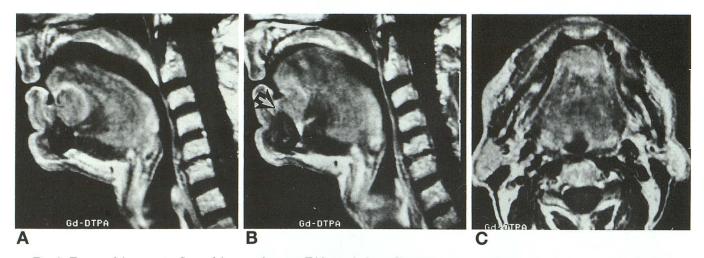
Tumor of the anterior floor of the mouth: stage T4 by pathology. Short-TR spin-echo T1-weighted sequences (180/15) in the sagittal plane (A and B) and in the axial plane (C) after gadopentetate dimeglumine infusion show a lesion of the anterior floor of the mouth, involving the alveolar ridge (*arrow*) but not infiltrating the cortical bone of the mandible.
